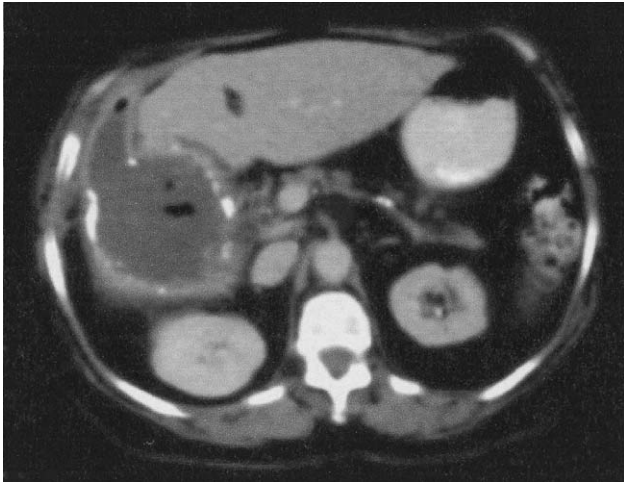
CT image of hydatid cyst with air-fluid level suggesting infection with abscess formation.
